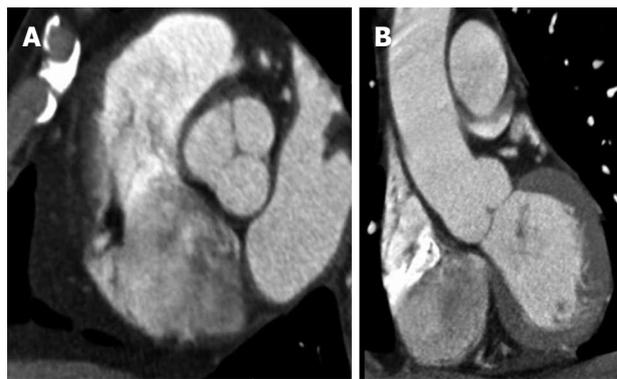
Cardiac-gated computed tomography aortogram in a 55-year-old with chest pain and suspected acute aortic syndrome. A: Axial oblique; B: Coronal reconstructions. No dissection or aneurysm was detected. Retrospective reconstruction at 78% of the cardiac cycle allowed for accurate evaluation of the aortic root and valve cusps in both axial oblique and coronal reconstructions with no pulsation artefacts.
